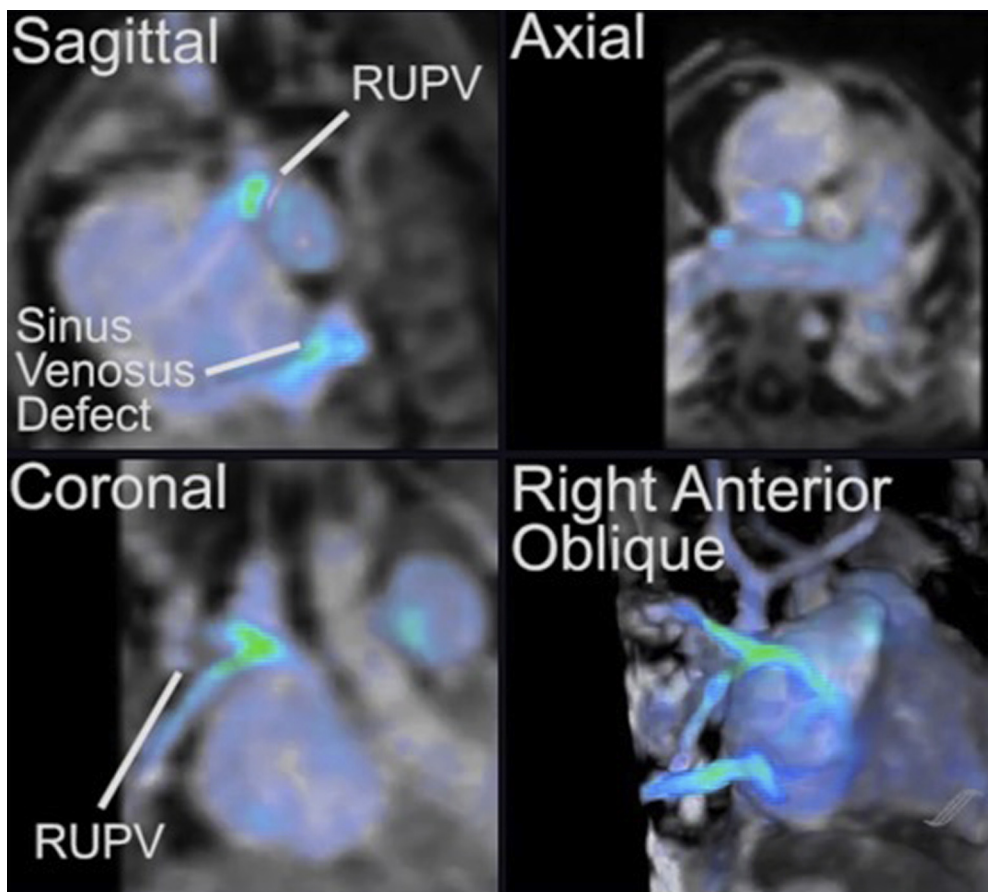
Cardiac magnetic resonance imaging with four-dimensional flow sequence from the sagittal view, coronal view, axial view, and right anterior oblique view as labeled, demonstrating pulmonary venous and atrial anatomy, inferior sinus venosus defect, and partial anomalous pulmonary venous return of the right upper pulmonary veins (RUPVs) to the superior vena cava–right atrium junction.
